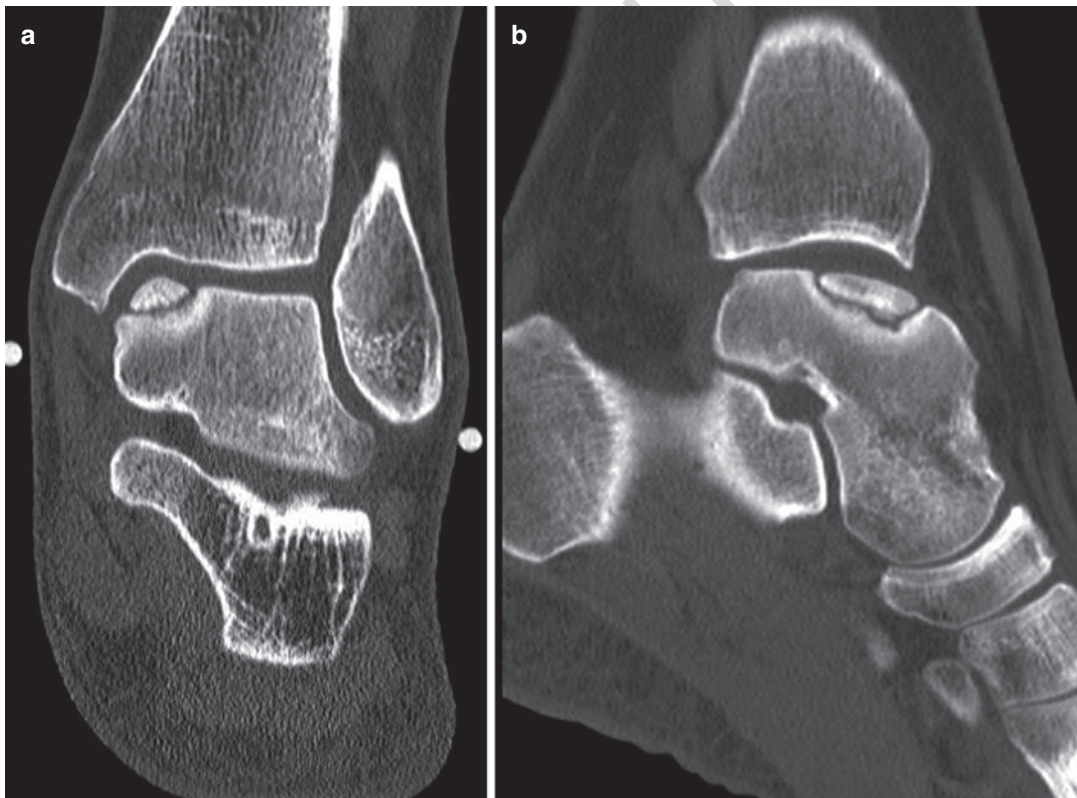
Coronal- (a) and sagittal- (b) computed tomography scan of an ankle in plantar flexion with an osteochondritis dissecans lesion
